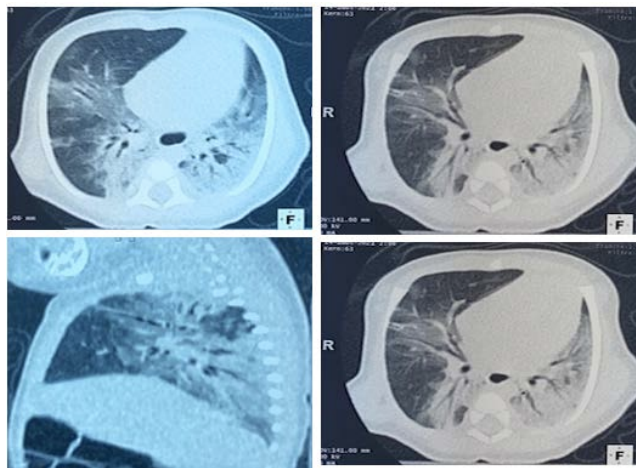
Chest CT (at admission). Chest CT (Figure 2) showed patchy ground-glass images associated with predominantly lower banded foci of condensation, and lesions extended to 75% of the lung.
